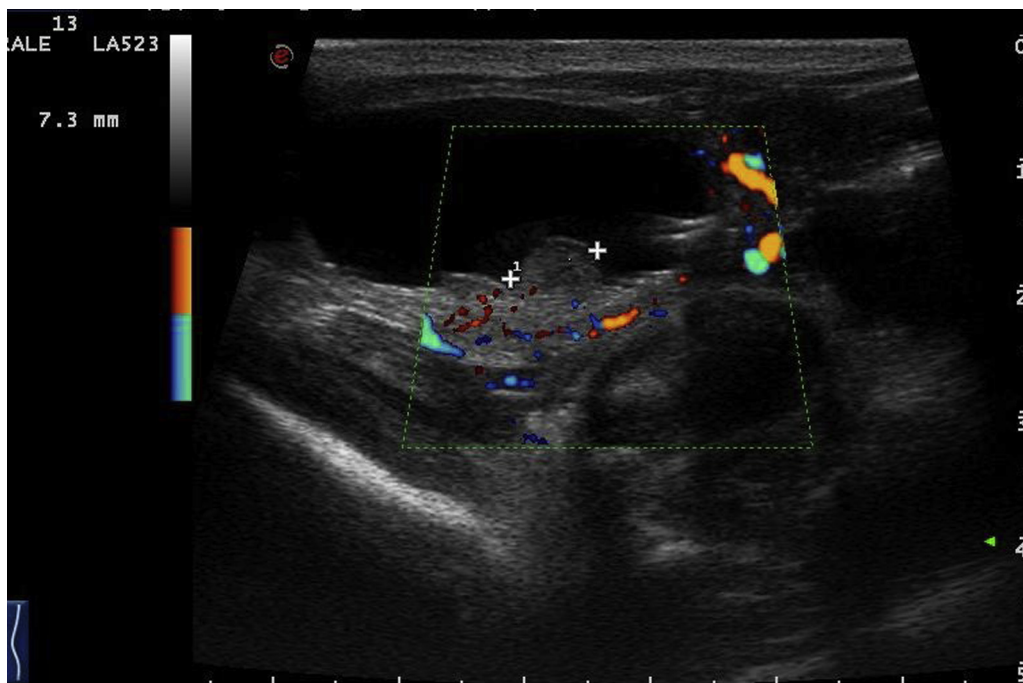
Bladder ultrasound shows a vascularized pseudopolypoid mass at the posterior wall of urinary bladder measuring 7 mm (maximum diameter). (Color version available online.)
